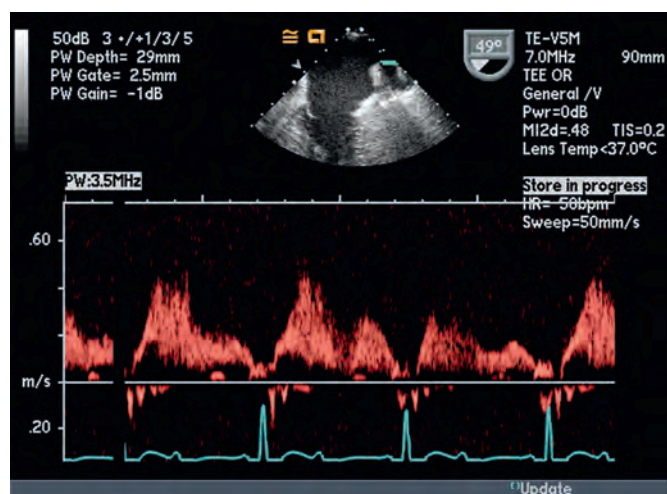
Pulsed-wave Doppler echocardiography of the left upper pulmonary vein found in the midesophageal two-chamber view. HR, Heart rate; PW, pulsed wave; TEE, transesophageal echocardiography.
